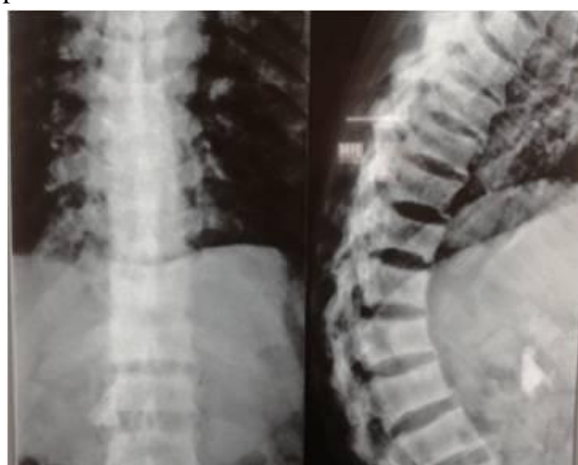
Chest X-Ray shows increased bone density, widening of ribs.
